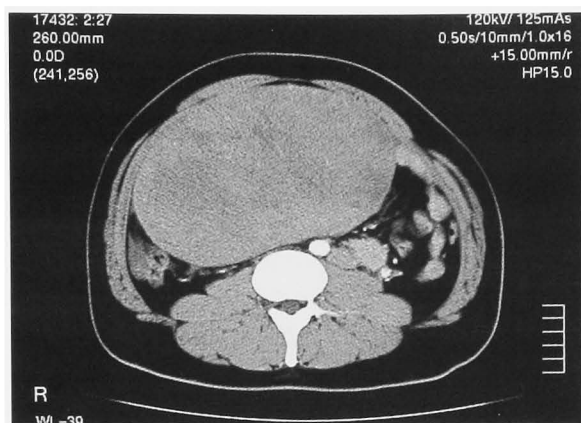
Abdominal CT revealed huge intraabdominal mass, which is not well enhanced.
